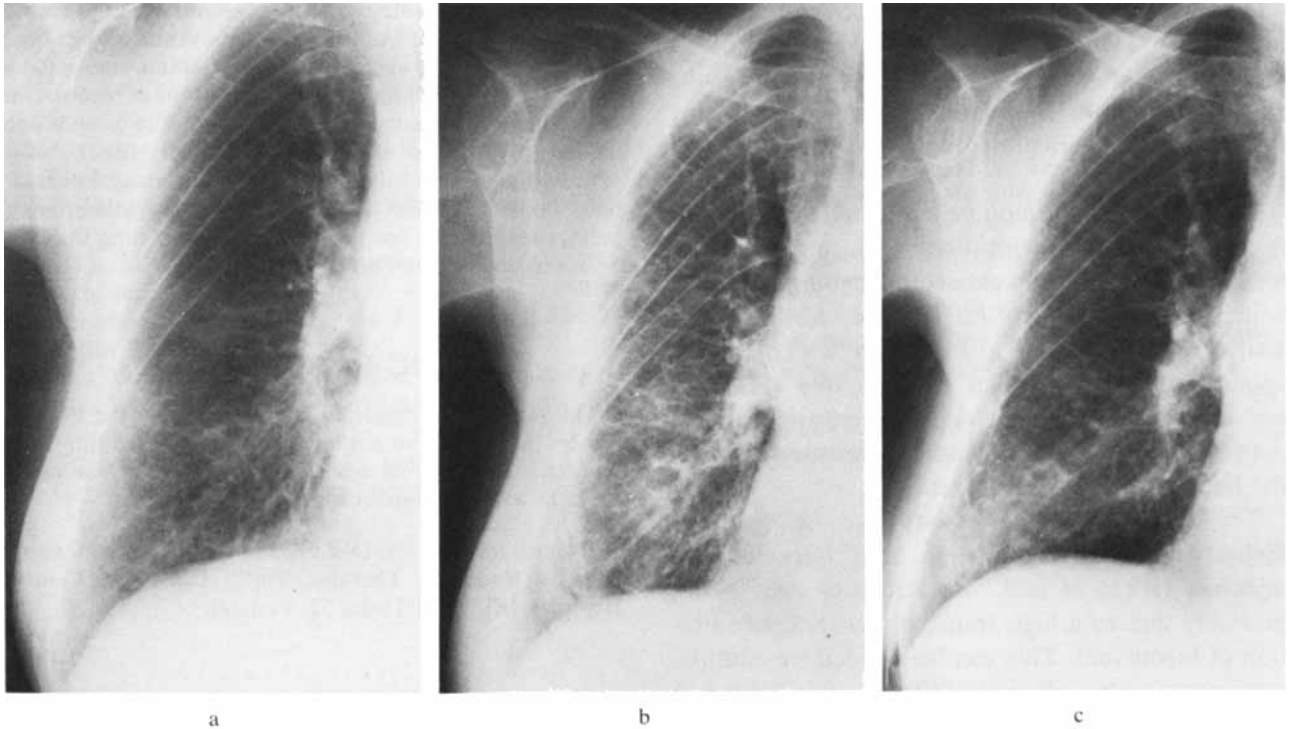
Woman aged 68 years. a) Conventional chest roentgenogram before treatment. b) Thickening of the laterobasal pleura and some parenchymal lesions 73 days after beginning of bleomycin
